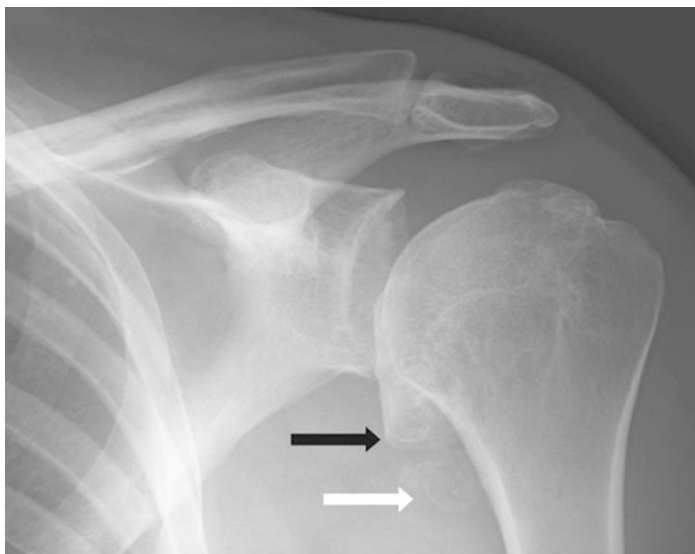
Degenerative changes of the glenohumeral joint, including osteophytes medially (black arrow) and inferiorly (white arrow) shown in the shoulder X-ray [9]
